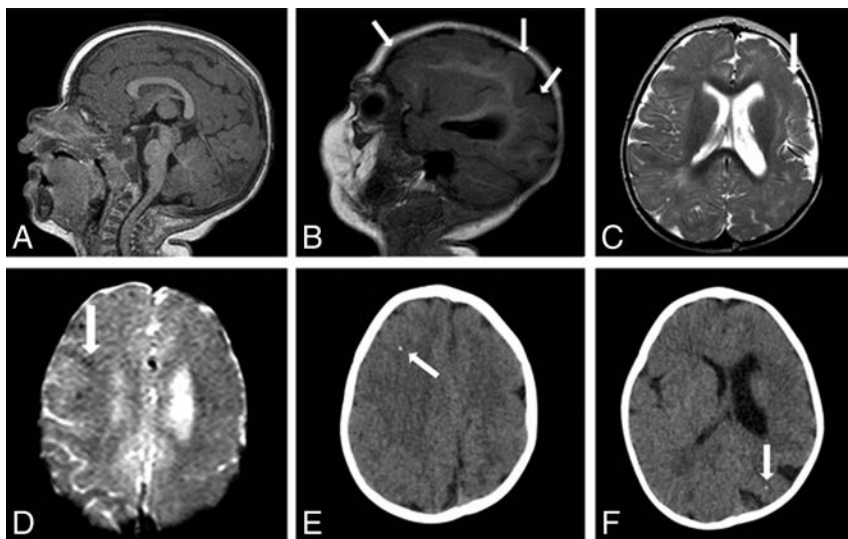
MR imaging and CT of an 11-month-old girl without microcephaly with probable congenital Zika syndrome. Sagittal T1-weighted image shows a normal corpus callosum and cisterna magna (A) and left polymicrogyria (white arrows) (B). Axial T2-weighted image (C) shows left polymicrogyria (white arrow) and mild left ventriculomegaly. A gradient-echo image (D) shows very few small and subtle punctate foci, representing calcifications, at the cortico-subcortical white matter junction (white arrow). Axial CT scans (E and F) show right frontal and left parietal punctate foci (white arrows).
